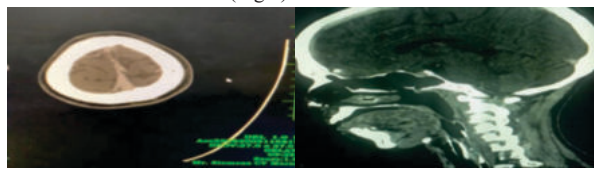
CT scan imaging of brain showing partial contrast filling defect in frontal portion of Superior Sagittal sinus
